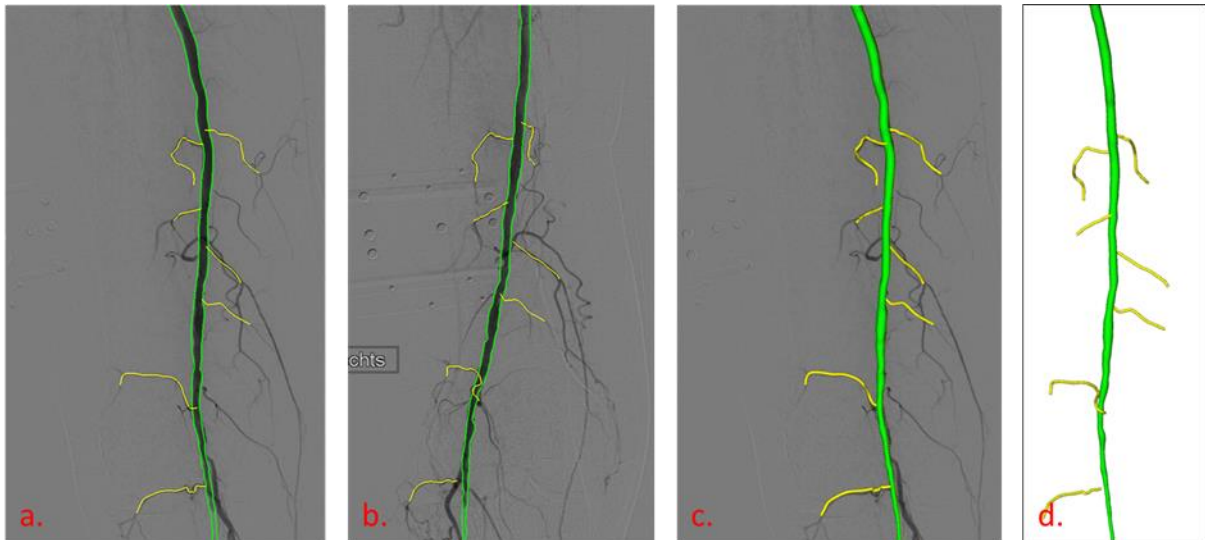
Pair of angiographic images with the semi-automatically extracted arterial tree (a) (b); reconstructed 3D arterial tree on top of a radiograph (c); the reconstructed 3D arterial tree (d).
